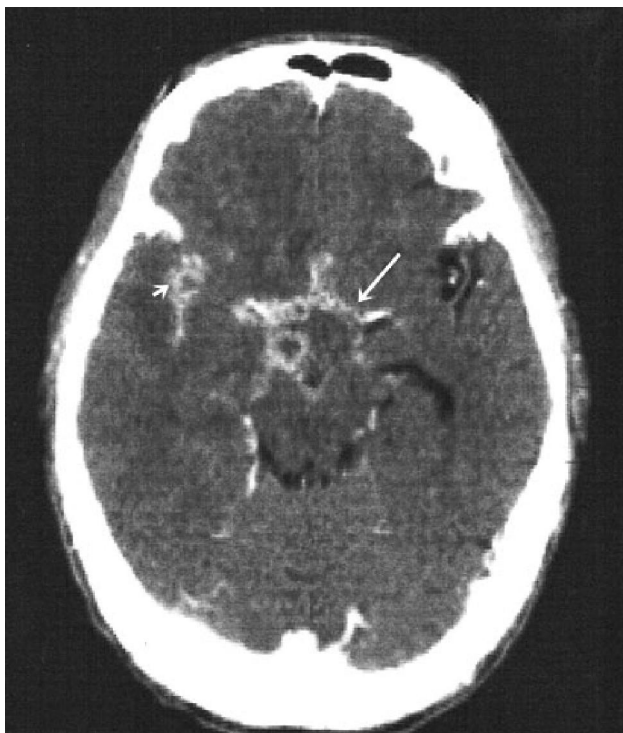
Contrast enhanced axial CT Brain scan shows marked leptomeningeal enhancement in suprasellar cistern, right sylvian fissure and a few of sulcal spaces suggestive of meningitis-Tuberculous?
